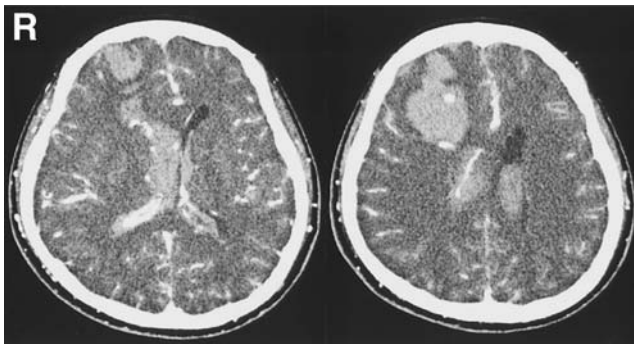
Computed tomography scans showing the hematoma in the right frontal lobe has enlarged and extended intraventricularly, and two structures were enhanced after administration of contrast medium.
